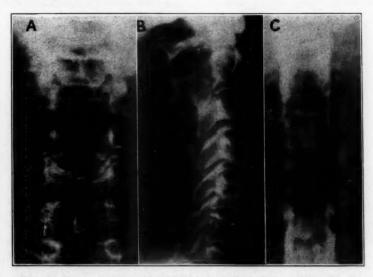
Roentgenograms of the cervical portion of the spine: A, anteroposterior view; B, lateral view. C is a myelogram of the cervical region.
